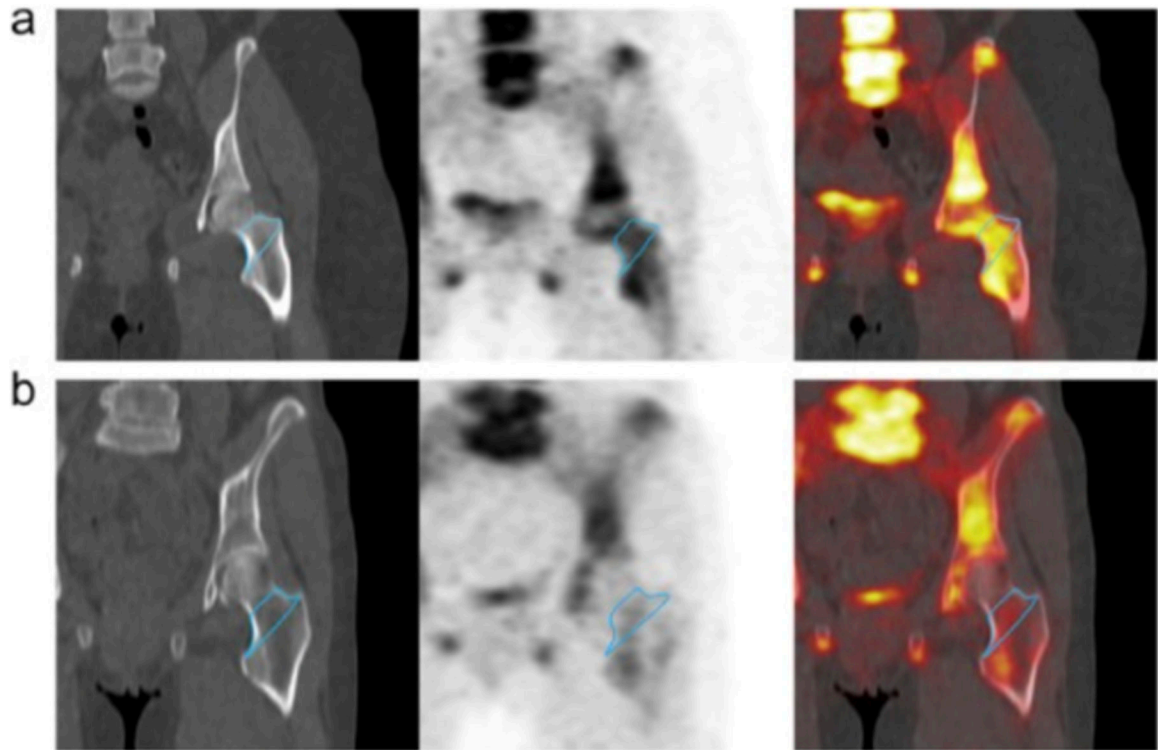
(A) The coronal section of a CT scan (left), static ^{18}F -NaF PET scan (middle), and a fusion of the two (right) at the left hip of a healthy, 25-year-old woman. (B) The same image sequence for a 62-year-old woman. Using the CT image to precisely segment the region of the femoral neck, the amount of radiotracer uptake within that commonly fractured region is easily quantified and can be used to track therapeutic response. (From Reilly CC, Raynor WY, Hong AL, et al. Diagnosis and Monitoring of Osteoporosis With ^{18}F -Sodium Fluoride PET: An Unavoidable Path for the Foreseeable Future. *Semin Nucl Med.* 2018;48(6):535–540.)
